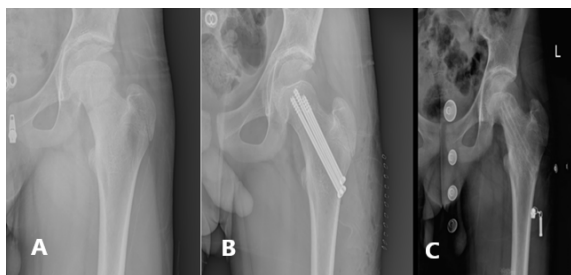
Delbett type 2 nondisplaced fracture in a 12 year- old boy. A. Preoperative roentgenogram. B. Postoperative roentgenogram showing fixation with cannulated screws C. Final roentgenogram after 14 months with no complication.
